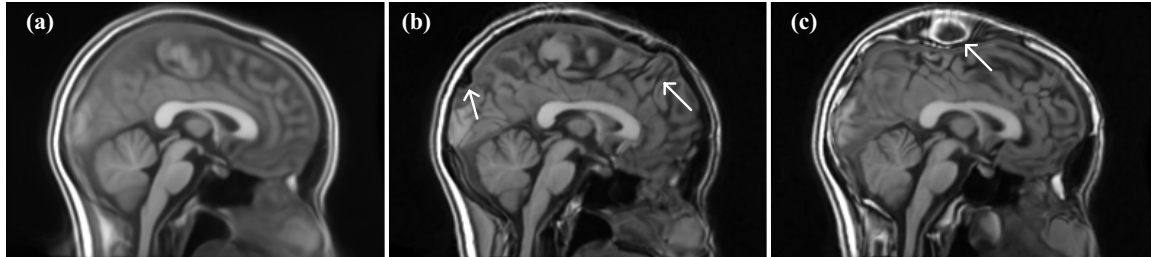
A sharp image averaged from non-rigid alignment results, (a), could not imply accurate registration, (b) and (c). Automated Registration Tool [123] was utilized in this example for the non-rigid registrations of 57 T1-weighted MR images.
